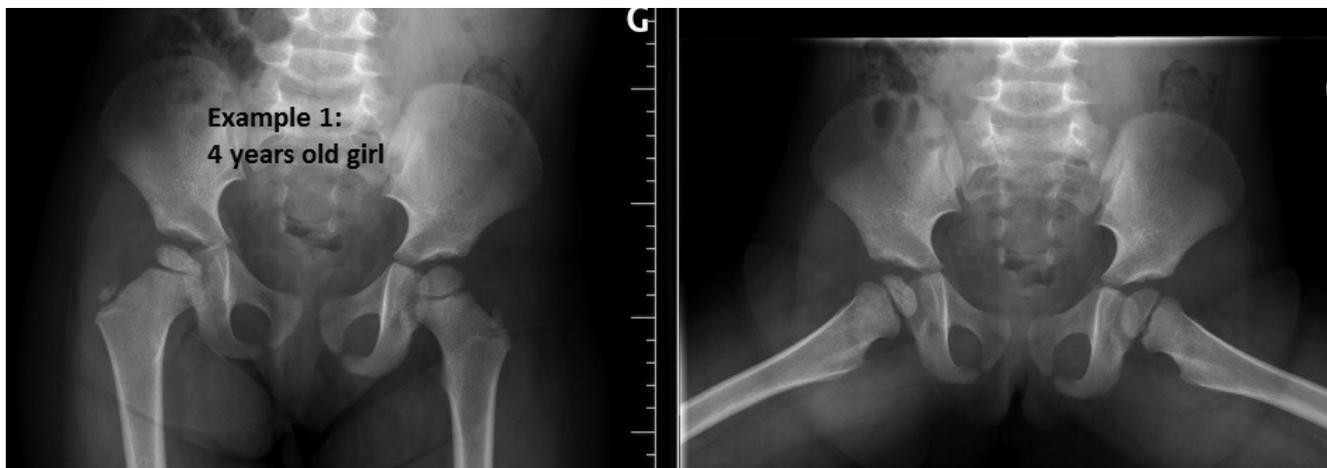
4 years old girl, pelvic X-Ray showing osteochondritis, Catterall 1, Herring A.
